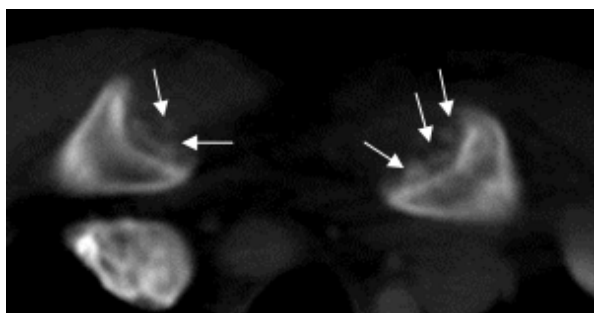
CT image of medial clavicles of a 18 year old male shows more than one ossification center on both sides (white arrows)
